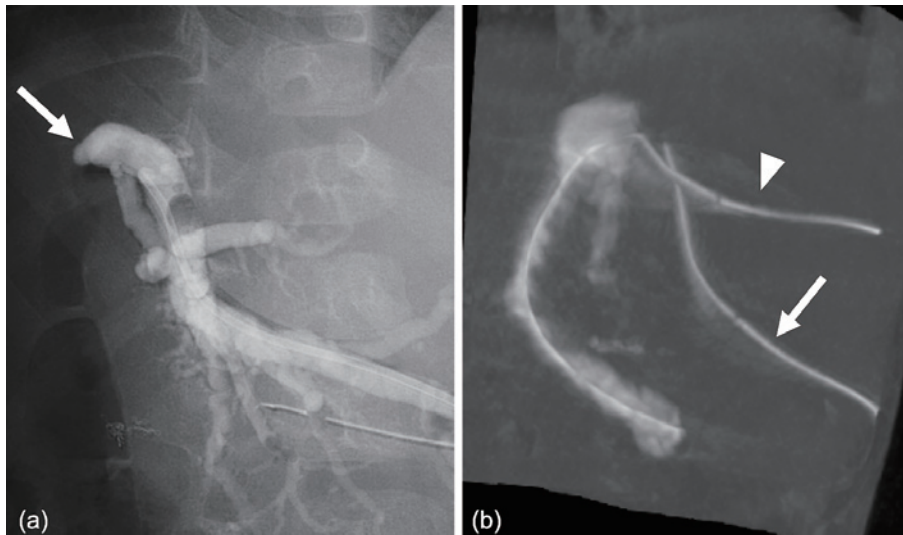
a) Cholangiogram shows the occluded bile duct anastomosis of B3 (arrow). b) Cone-beam CT after PTBD from B2 reveals a skew position between the catheters in B3 (arrow) and B2 (arrowhead).
